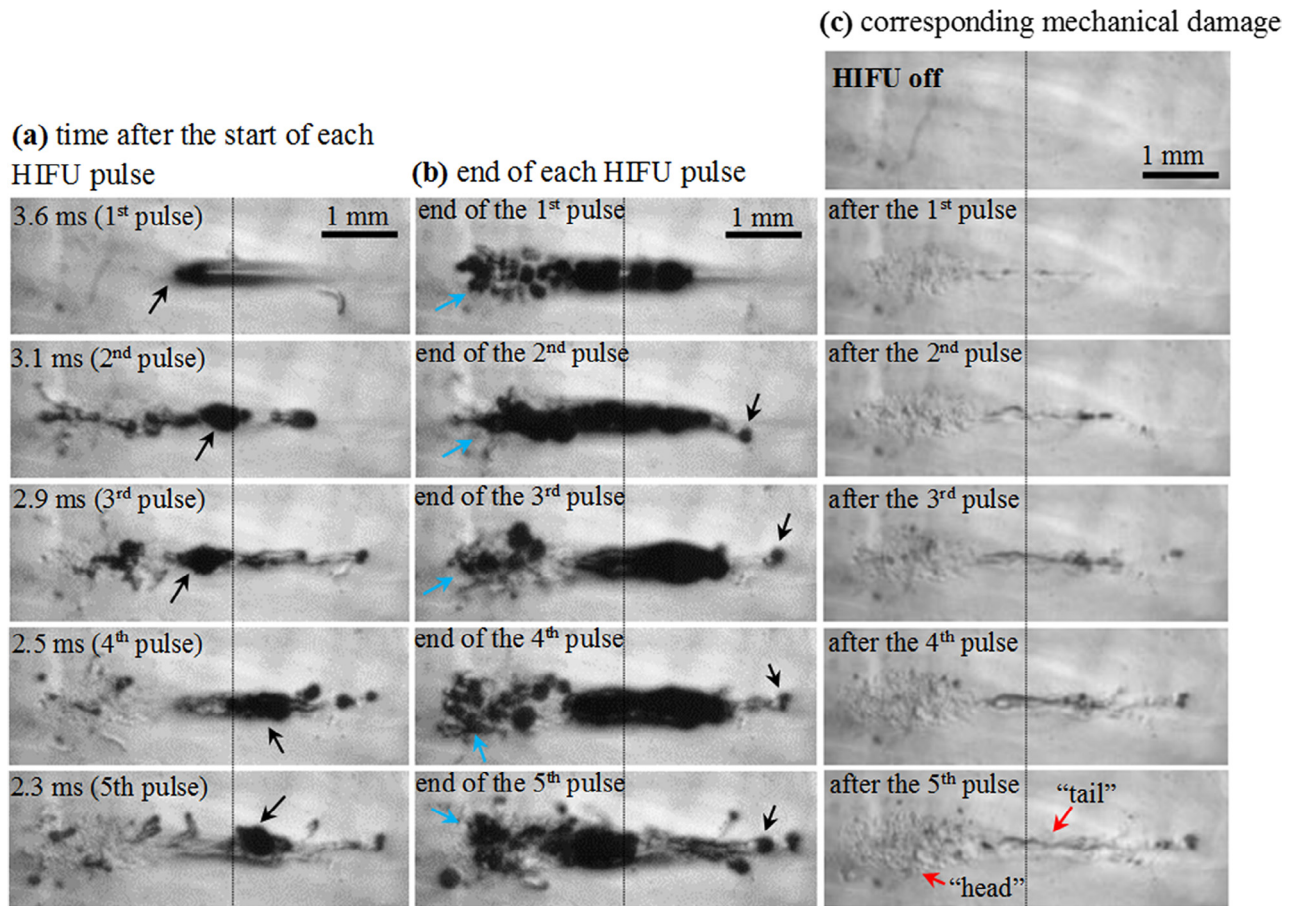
High-speed images taken during five HIFU pulses. (a) Formation of a boiling bubble during each HIFU pulse (*left column*). (b) The end of each pulse (*middle column*). (c) Corresponding mechanical damage induced in the gel before the arrival of the next HIFU pulse (*right column*). The HIFU beam propagates from left to right. The images were captured at a frame rate of 15,000 fps. The vertical lines pass through the HIFU focal point perpendicular to the beam axis. HIFU = high-intensity focused ultrasound; fps = frames per second.
